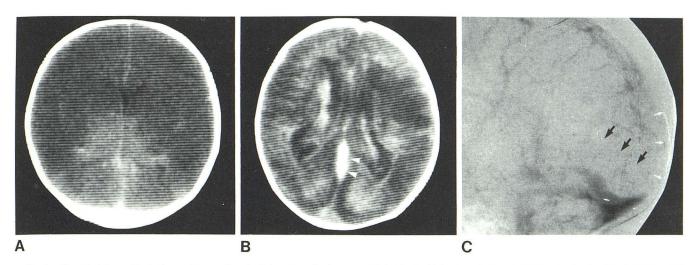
Case 1, intraventricular hemorrhage and sagittal sinus thrombosis. A, CT without contrast shows decreased attenuation of white matter with compression of ventricles. B, CT without contrast 14 days after anoxic episode shows mild intraventricular hemorrhage, parenchymal hemorrhage, enlarged
